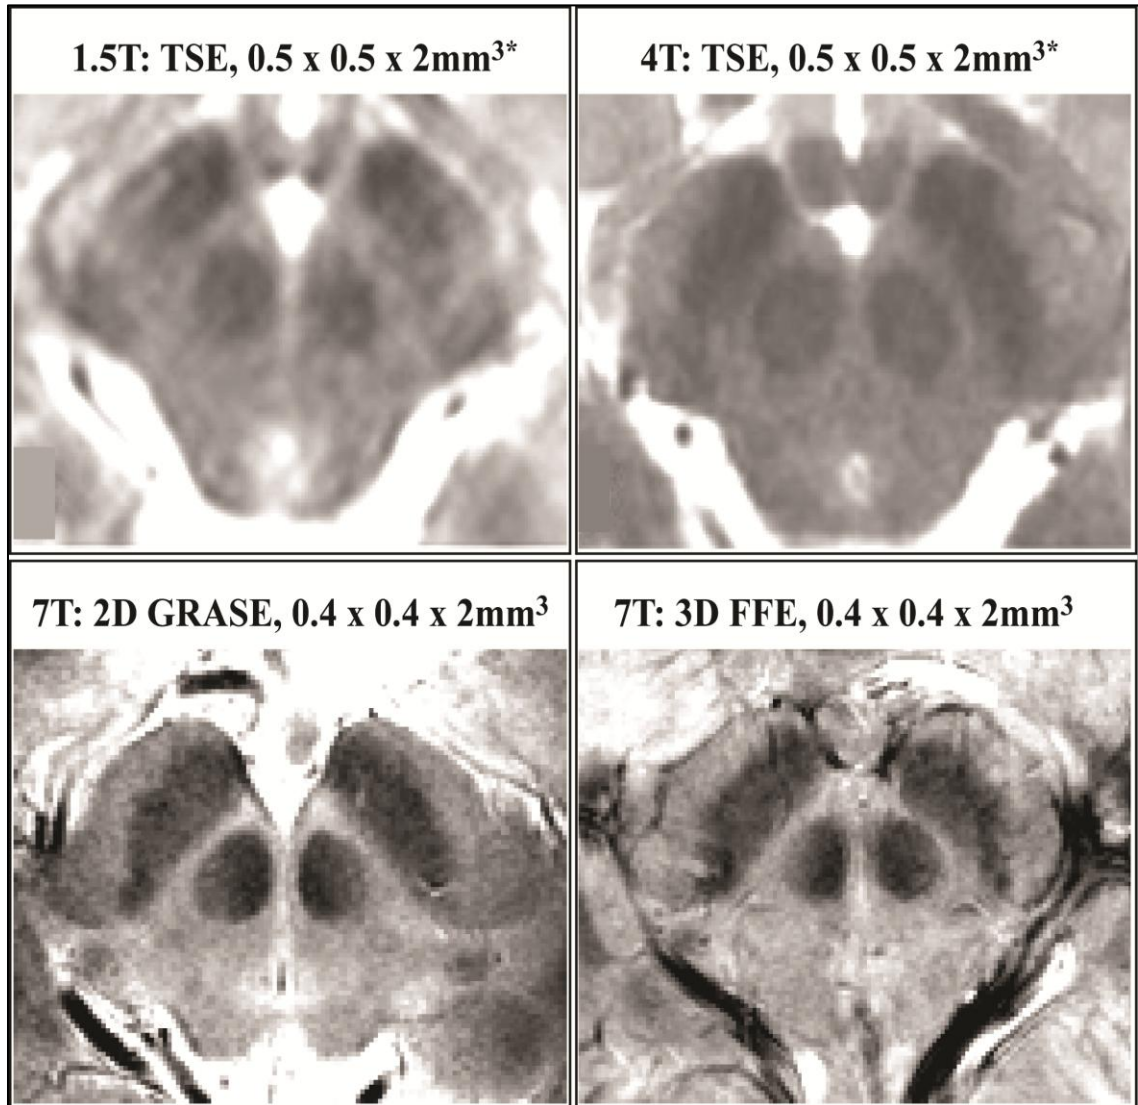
MRI of the midbrain at different field strengths. Comparable spatial resolutions at the level of the superior colliculus are presented here for 1.5 Tesla, 4 Tesla and 7 Tesla. TSE: Turbo Spin Echo sequence; GRASE: GRAdient and Spin Echo sequence; FFE: Fast Field Echo. The 7 T images were taken at the VUIIS 7 T MR scanner. *(Manova, Habib et al. 2009).
